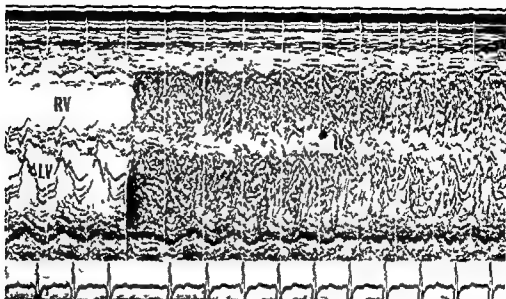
In this echocardiogram of the right (RV) and left ventricle (LV) the echo reflecting surfaces are present in both chambers indicating a large intracardiac right to left shunt The ventricular septum (IVS) is clean suggesting atrial shunting
